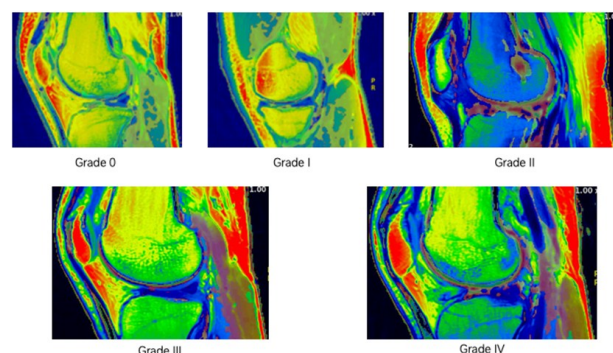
MRI grading criteria for the severity of cartilage degeneration of the knee joint.
